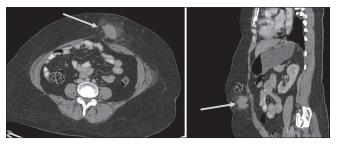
(a) Axial and (b) Sagittal section of the contrast-enhanced computed tomography scan of the abdomen shows an irregular heterogeneously enhancing lesion (arrow) measuring $1.9 \text{ cm} \times 3.3 \text{ cm} \times 3.1 \text{ cm}$ in the anterior abdominal wall at the left paramedian location with mild adjacent fat stranding and a small incisional hernia
